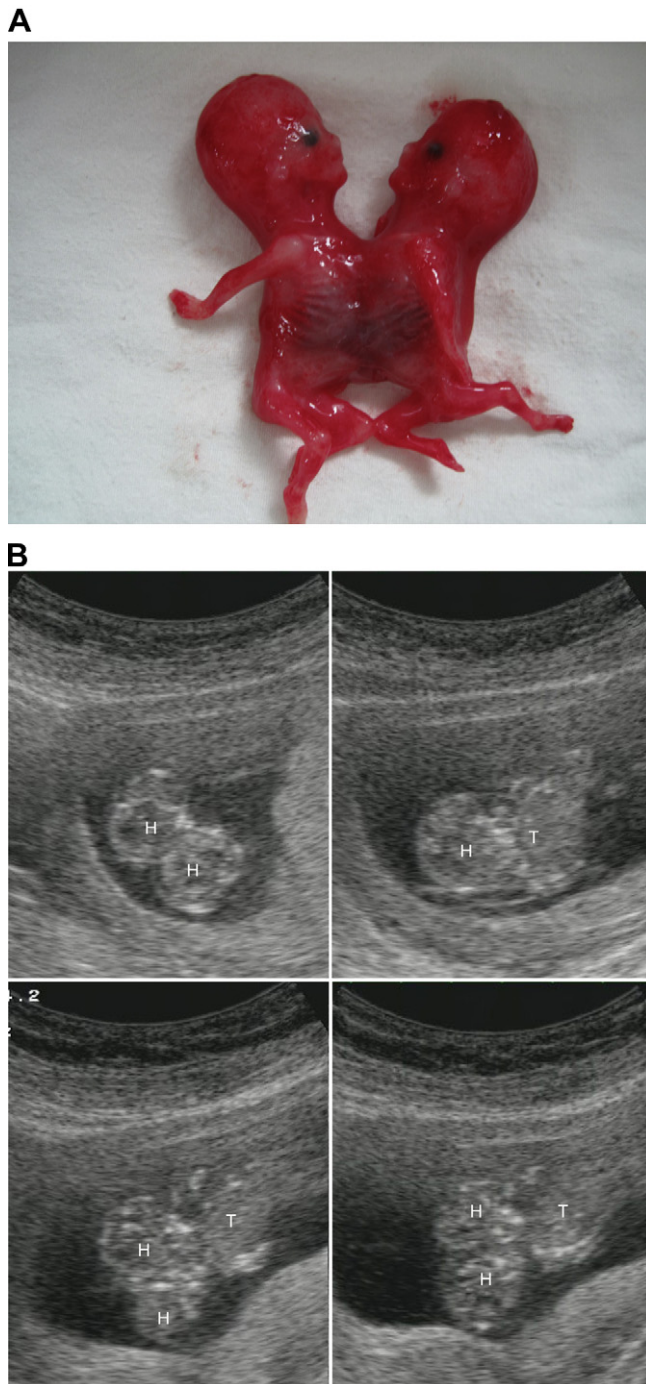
Case 2. (A) A case of thoracoomphalopagus delivered at 11 weeks of gestation. (B) Two-dimensional (2D) ultrasound of thoracoomphalopagus at 10 weeks of gestation. H = head, T = thorax.
